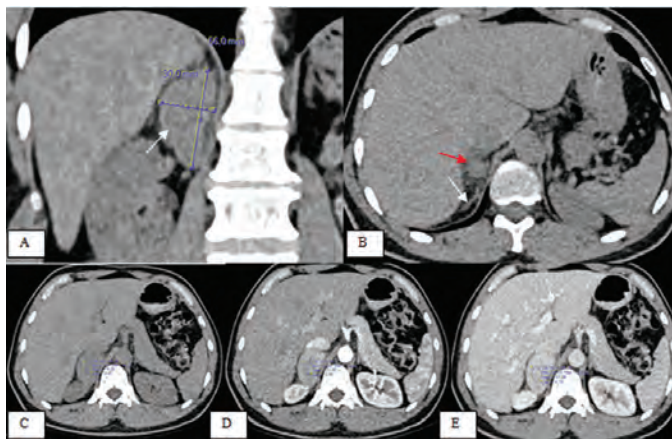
(A, B) Non-contrast CT images showing the right adrenal mass-measuring 56x30 mm on coronal image (A, arrow). On axial images the lateral limb of the right adrenal gland is shown, but corpus of the rest of the gland was not visible (B, white arrow). The part of the mass that should not be discerned from the adrenal gland is shown (B, red arrow). (C-E) Contrast washout CT scan demonstrates soft tissue density of the lesion on non-contrast CT (C) and progressive enhancement during the arterial (D) and venous (E) phases
